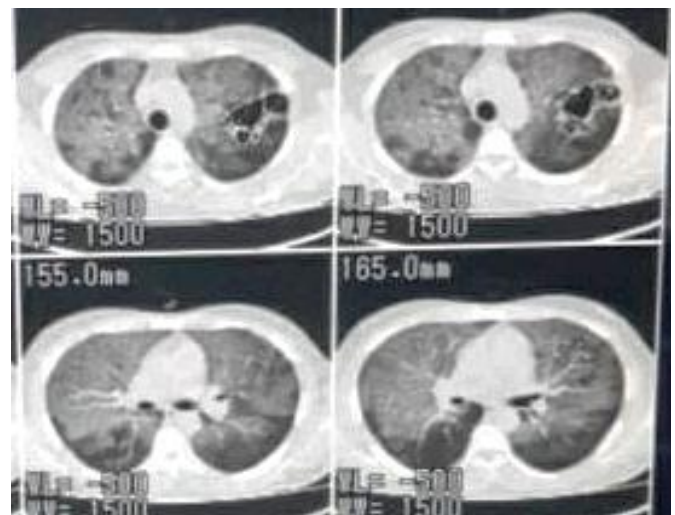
HRCT showed multiple areas of central alveolar consolidation with air trapping and cystic change
